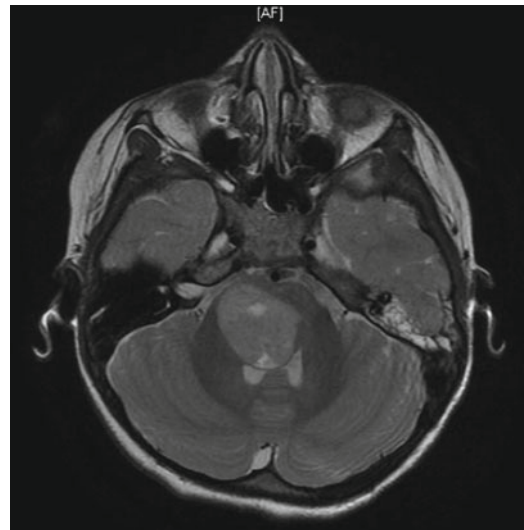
Neuroectodermal tumor, grade IV, of the pons. T2 weighted MRI brain demonstrating a mass lesion with cystic elements and compression of the fourth ventricle
